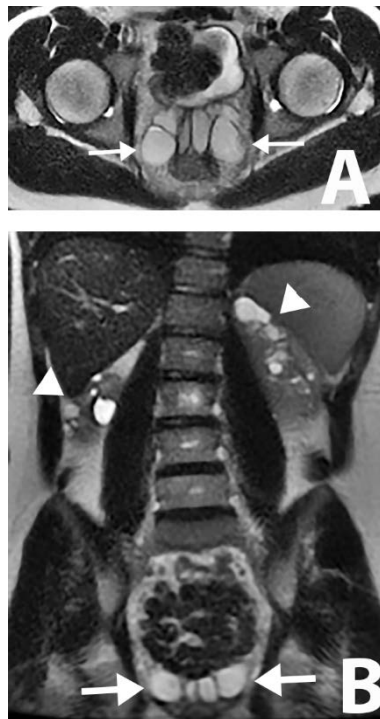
An example of abnormal seminal vesicles. A 19 year old male, diagnosed with ADPKD on ultrasound, without family history. Bilaterally dilated hyperintense seminal vesicles on single shot fast spin echo (SSFSE) images (axial and coronal images) on 1.5 T MR, measuring 1.9 cm on the left and 2.1 cm on the right. No reproductive symptom was reported at the time of imaging and no fertility evaluation was performed. Normal serum creatinine. A, Axial SSFSE image; B, Coronal SSFSE image, demonstrating dilated both seminal vesicles (arrows) and multiple cysts in both kidneys (arrowheads).
